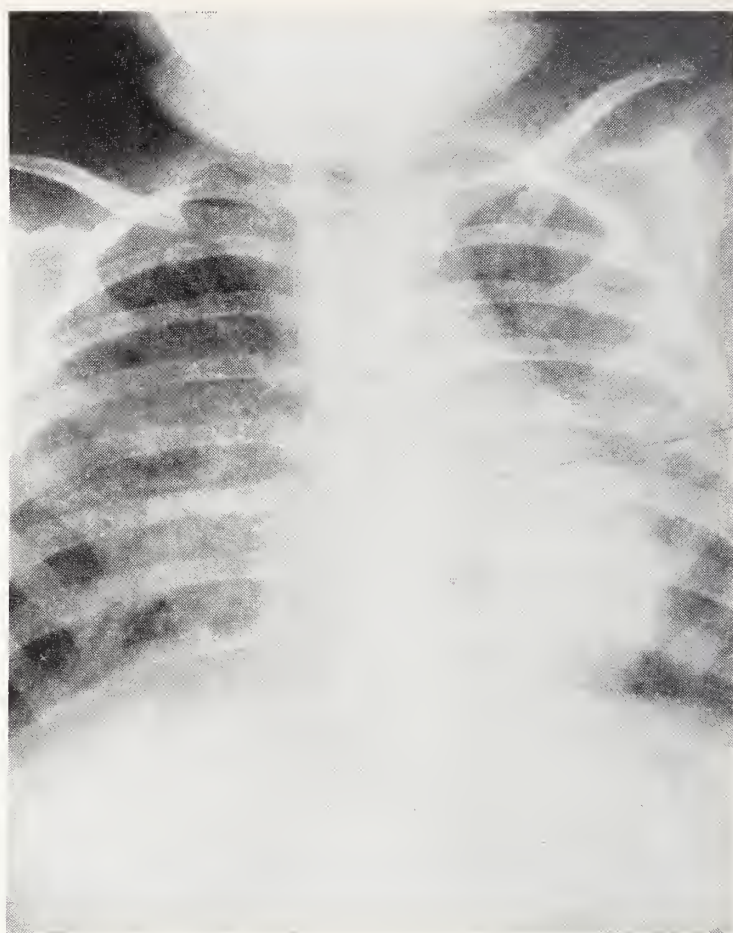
Case 4. Chest radiograph one hour after ingestion of unknown amount of kerosene.
